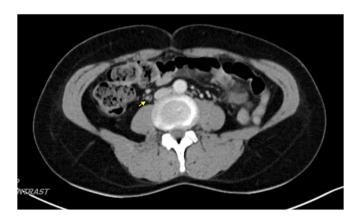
Axial contrast-enhanced CT demonstrated right ovarian vein (arrows) with resolved thrombus.
